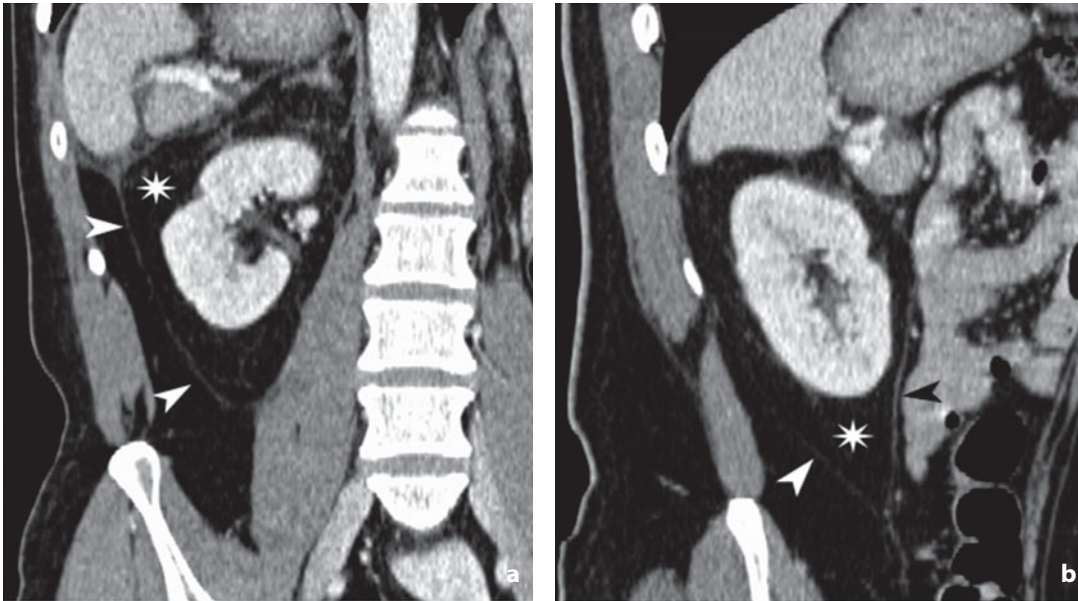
Computed tomography. Coronal reconstructions. Kidney area. The renal fascia (*arrowheads*) are visible as hyperattenuating thin lines. The asterisk indicates the perirenal space
